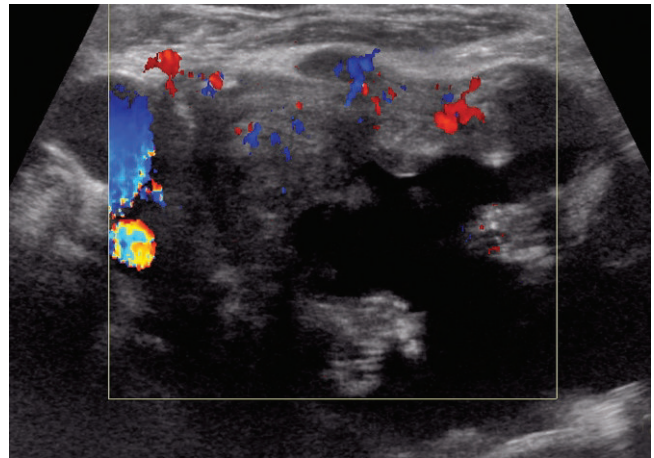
The transverse color Doppler sonographic image of a different patient shows a large, solid, hypoechoic/heterogeneous thyroid mass in the right lobe with a large area of cystic change. There is some internal vascularity.
